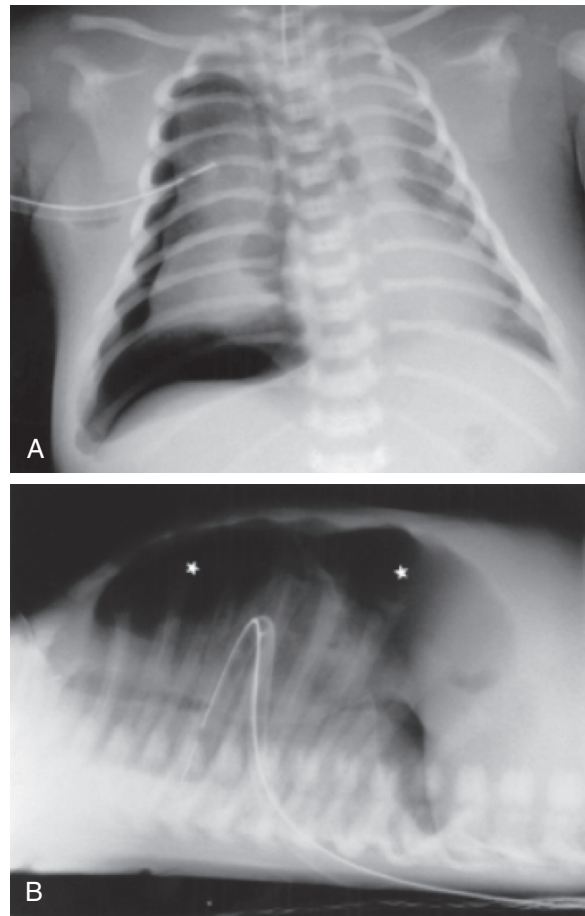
(A) Right-sided tension pneumothorax incompletely drained by the intercostal drain. There is flattening of the diaphragm and a shift of the midline with compression of the left lung. (B) Lateral view shows that the chest drain is angulated posteriorly and is not ideally sited to drain the anterior and subpulmonary collection of air (*asterisk*). (From Arthur R: The neonatal chest x-ray. *Paediatr Respir Rev* 2:311, 2001.)
